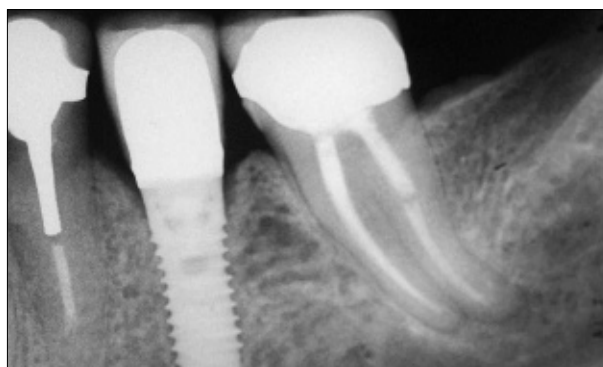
Periapical radiograph of the implant at site 35 and the crown, 2 years after the restoration was placed. Slight crestal bone loss was apparent on the distal aspect of the implant.
